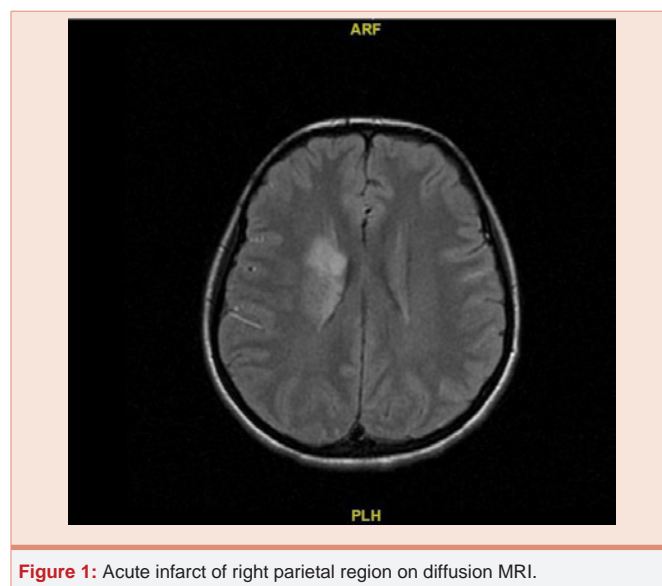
Acute infarct of right parietal region on diffusion MRI.
